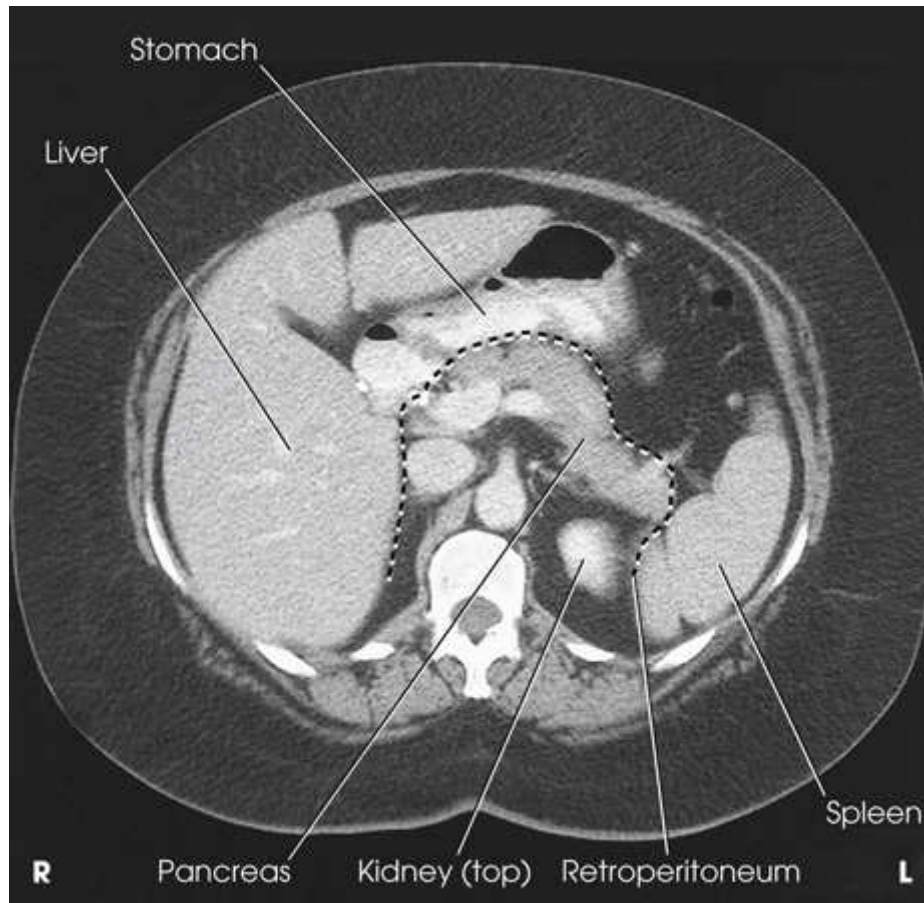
Axial CT image of abdomen showing organs of upper abdomen. Retroperitoneum is posterior and medial to *dashed line*. From Kelley LL, Petersen CM. *Sectional Anatomy for Imaging Professionals*. 2nd ed. St. Louis: Mosby; 2007.
